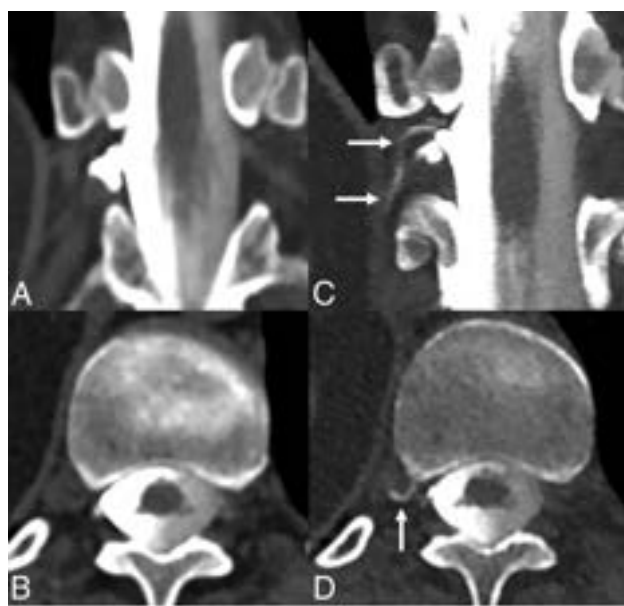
A 55-year-old woman with SIH according to the ICHD-3 criteria, including dural enhancement and venous distention on brain MR imaging (not shown). Coronal and axial images from a right lateral decubitus dynamic CTM (A and B) on an EID scanner reconstructed at 0.6 mm show no clear CVF. Subsequent PCD CTM with the patient in the right lateral decubitus position, including 0.2-mm coronal and axial reconstructions (C and D), shows a clear right T11 CVF (C and D, arrows).
